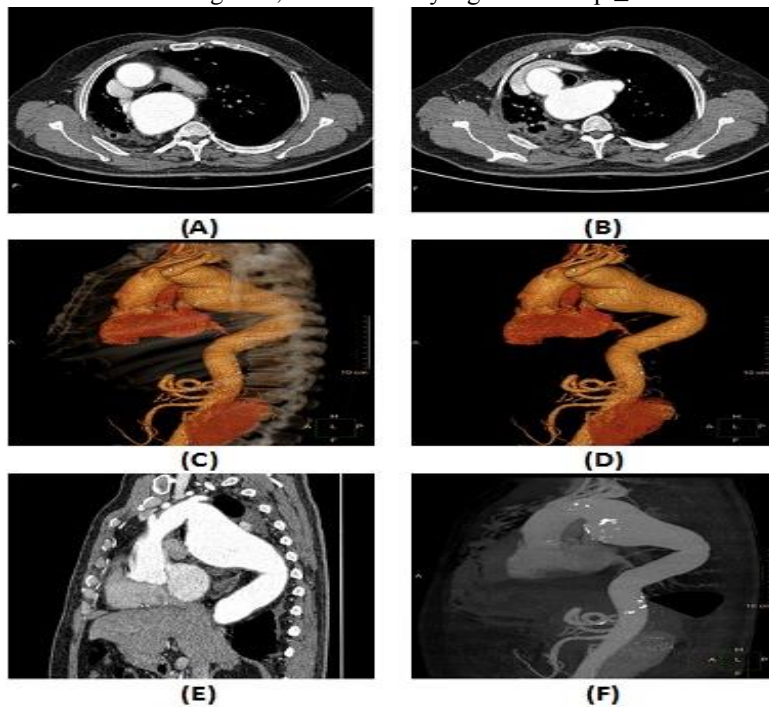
Case of right sided aortic arch with aberrant left subclavian artery and aortic aneurysm in a male patient aged 60 years old presented with dyspnea, dysphagia and chest pain. (A, B) post-contrast axial CT images showed right sided aortic arch with aberrant left subclavian artery and aneurysmal dilatation of proximal part descending aorta and first centimeters of left subclavian artery. Mild atherosclerotic changes are also noted. No dissection could be detected. (C, D) volume rendering imaging technique. (E) sagittal reconstructed image with curved image technique. (F) MIP imaging technique.
